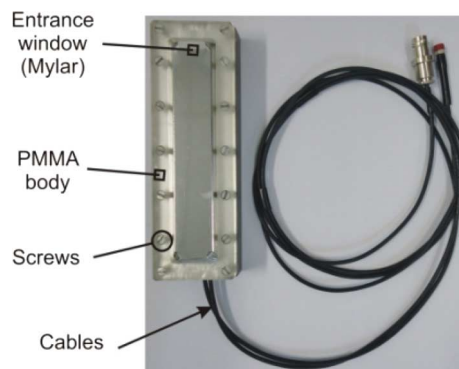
PPCT ionization chamber developed at the LCI [3] and characterized in this work at CT and diagnostic radiology standard qualities.
